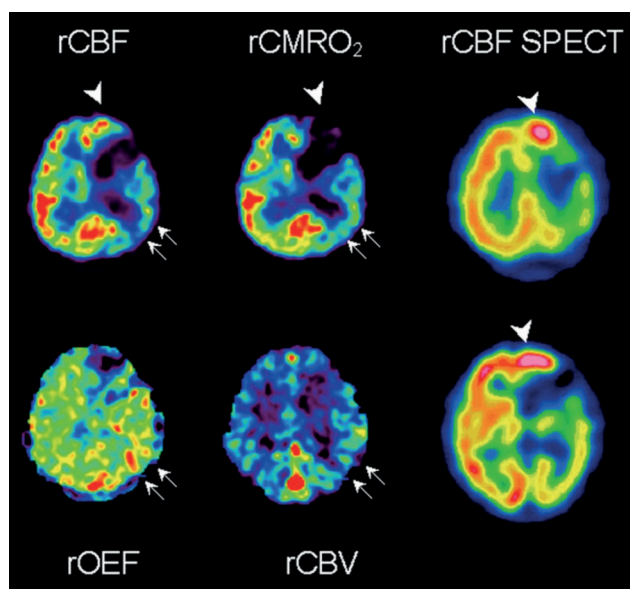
A case of subacute left-hemispheric stroke caused by left internal carotid occlusion. A ^{15}O PET study (left and center column) clearly demonstrates luxury perfusion in the left frontal cortex (arrow-head). SPECT perfusion imaging using $^{99\text{m}}\text{Tc}$ -HMPAO (right column) demonstrates hyperperfusion and hyperfixation in the same region (arrowhead). Misery perfusion is also seen in the left temporo-occipital region (small arrows). rCBF = regional cerebral blood flow, rCBV = regional cerebral blood volume, rCMRO₂ = regional cerebral metabolic rate of oxygen, rOEF = regional oxygen extraction fraction. Reproduced with permission from Ref. [74].
